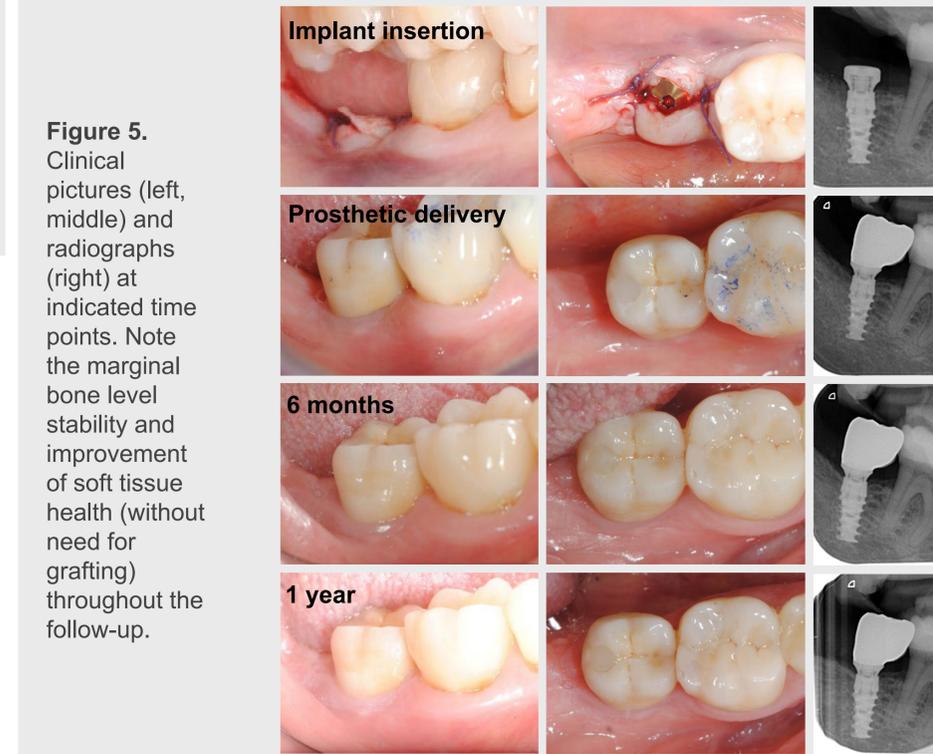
Clinical pictures (left, middle) and radiographs (right) at indicated time points. Note the marginal bone level stability and improvement of soft tissue health (without need for grafting) throughout the follow-up.
